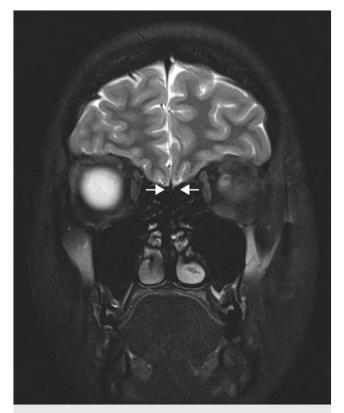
Lack of olfactory bulbs or tracts (*arrows*) in a 21-year-old woman with congenital anosmia on a T2-weighted high-resolution coronal magnetic resonance image.
